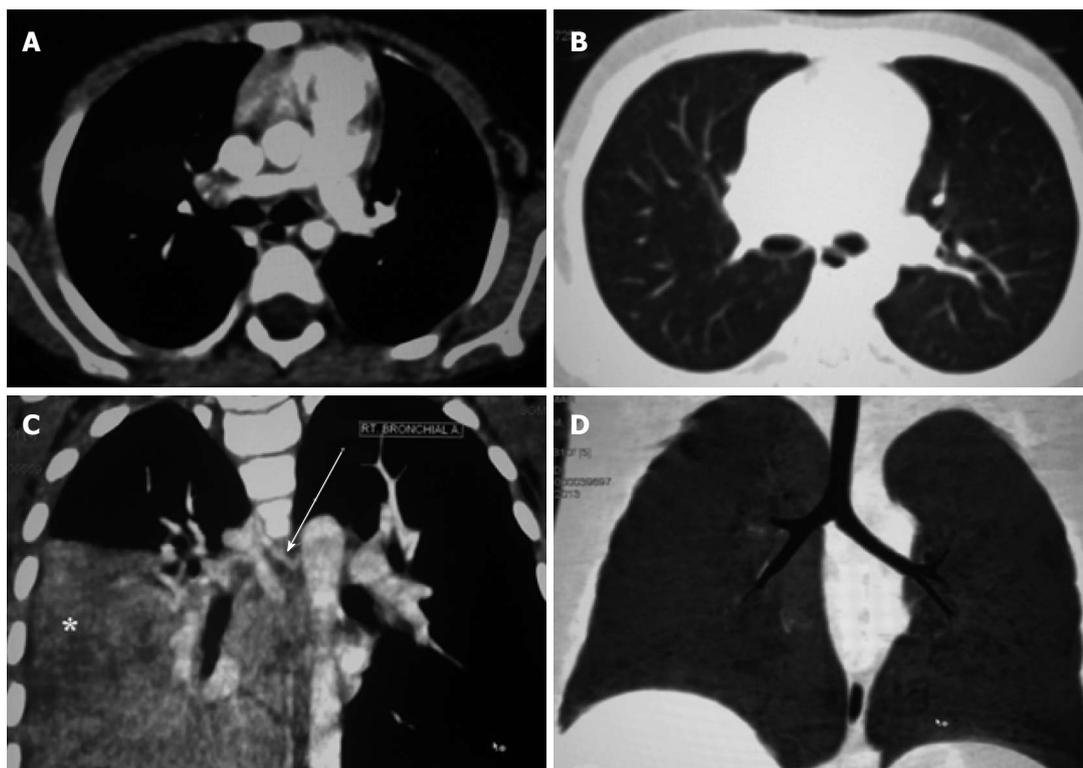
Multi-detector computed tomography image interpretation. Axial computed tomography image showing mediastinal window (A) and lung window (B). Coronal maximum intensity projection image (C) demonstrating the origin and proximal portion of the right bronchial artery (arrow). There is consolidation in the right lower lobe (asterisk). Coronal Minimum Intensity Projection image (D) delineating the central airways.
